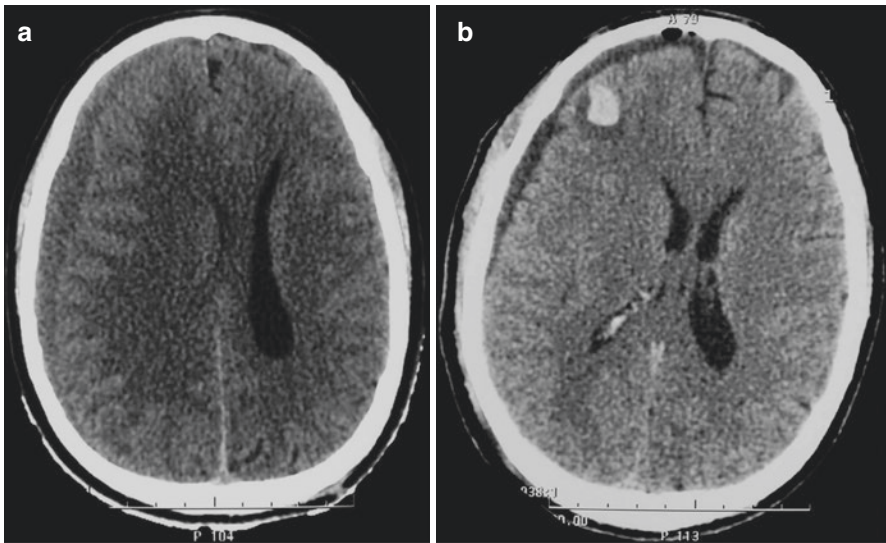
Postoperative remote brain hematoma in the right frontal lobe following surgical evacuation of a chronic SDH. Initial axial cranial CT scan (a) and on the third postoperative day (b)
